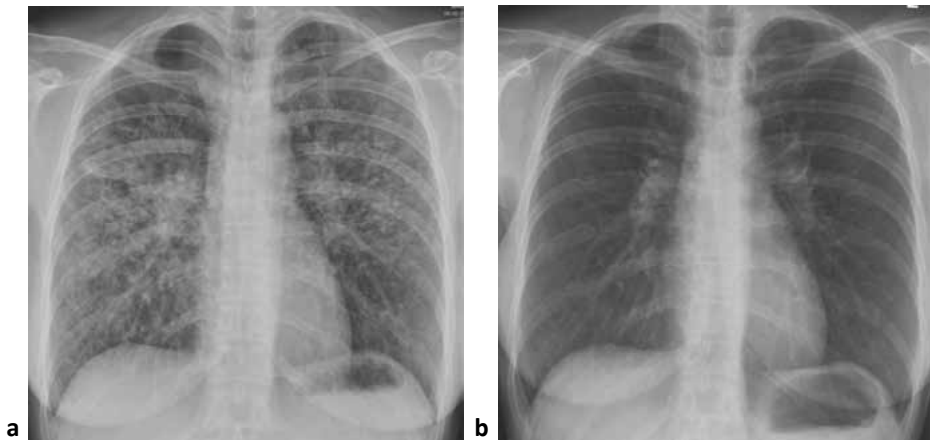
A 38-year-old woman had a 1-year history of biopsy-proven sarcoidosis. She had been previously treated with oral prednisone, starting at 40 mg daily, because of respiratory functional impairment, fatigue, exercise intolerance and signs of inflammatory activity (soluble-interleukin2-receptor was 3117 pg/mL, normal range 0-2500 pg/ml). However, no improvement was achieved, so methotrexate (MTX) was started at 12.5 mg once a week orally, together with folic acid 5 mg twice a week. Additionally, treatment with prednisone was tapered off to 7.5 mg daily. Due to gastrointestinal side-effects – mainly nausea – after MTX initiation, the administration of MTX 12.5 mg once a week was changed from oral to subcutaneous. a. Chest radiograph before treatment with subcutaneous MTX showed both lymphadenopathy and multiple parenchymal infiltrates. b. Chest radiograph after 5 months of treatment with subcutaneous MTX showed substantial improvement. Patient also reported significant clinical improvement after treatment with subcutaneous MTX.
